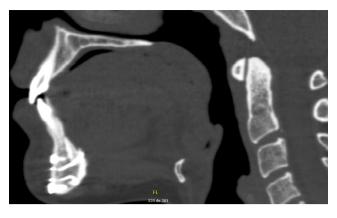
Postoperative control CT scan, showing the widening of the airway after repositioning of the geni tubercles. Sagittal view.
